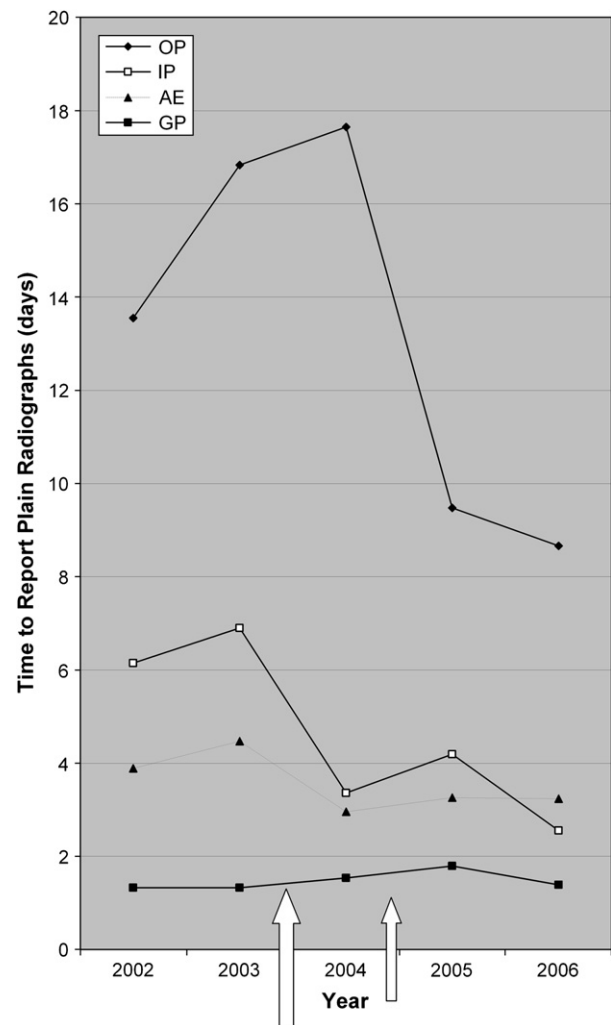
Plain radiograph reporting times (days) 2002–2006.
